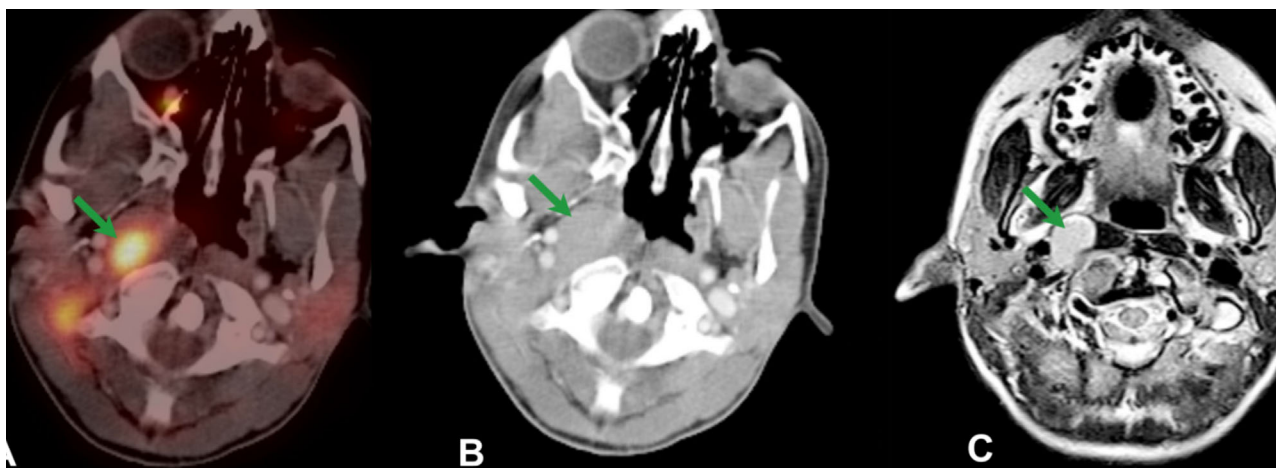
Patient with asymmetric Waldeyer's ring on ¹⁸F-FDG-PET imaging (A) explainable on CT and MR images by a retropharyngeal lymph node directly adjacent to the right palatine tonsil (B and C)
